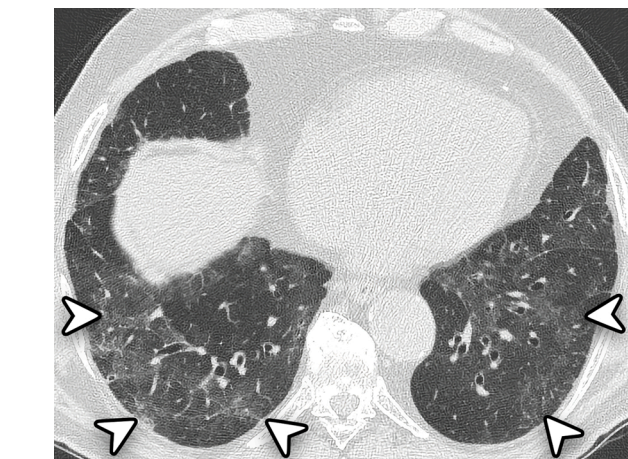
Unenhanced chest CT scan of a 59-year-old man who suffered severe COVID-19. The examination was performed 84 days after the disease onset. Axial image shows lower lobe predominant ground-glass opacity admixed with reticulation (white arrowheads) and relative sparing of the subpleural lung, suggesting a non-specific interstitial pneumonia pattern.
